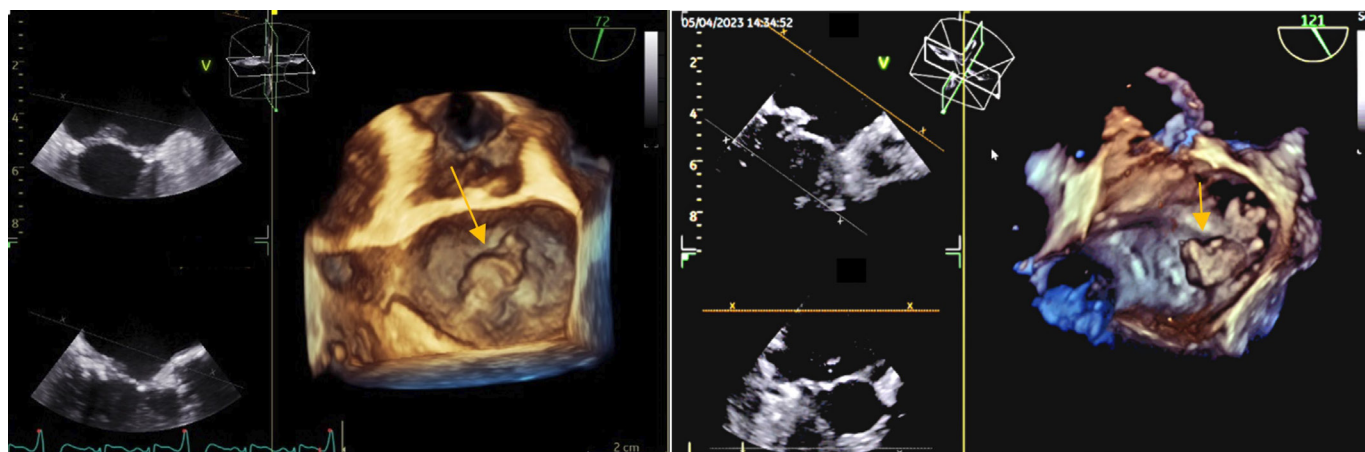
Three-dimensional transoesophageal echocardiography enface view—vegetation (arrows) on the posterior mitral valve (scallop P2).
